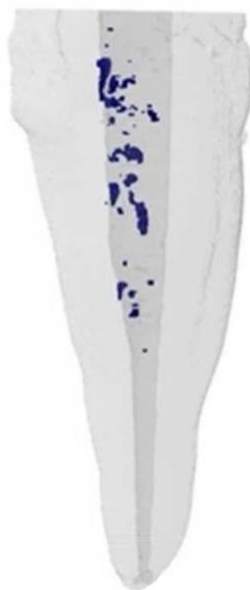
Preoperative micro-computed tomography visualization of the post space volume.
